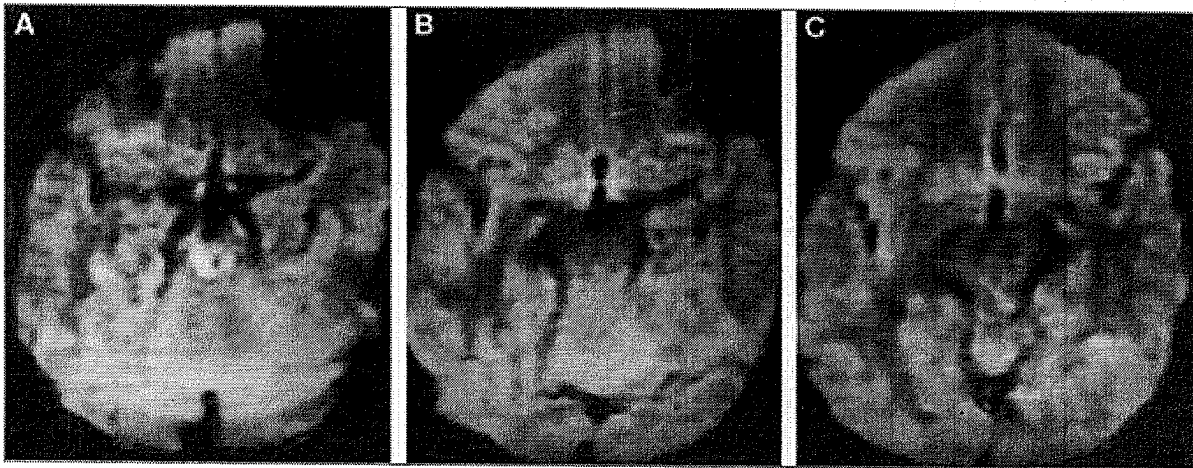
Diffusion MRI scans showing no evidence of infarction in the region of T2 midbrain signal change.
